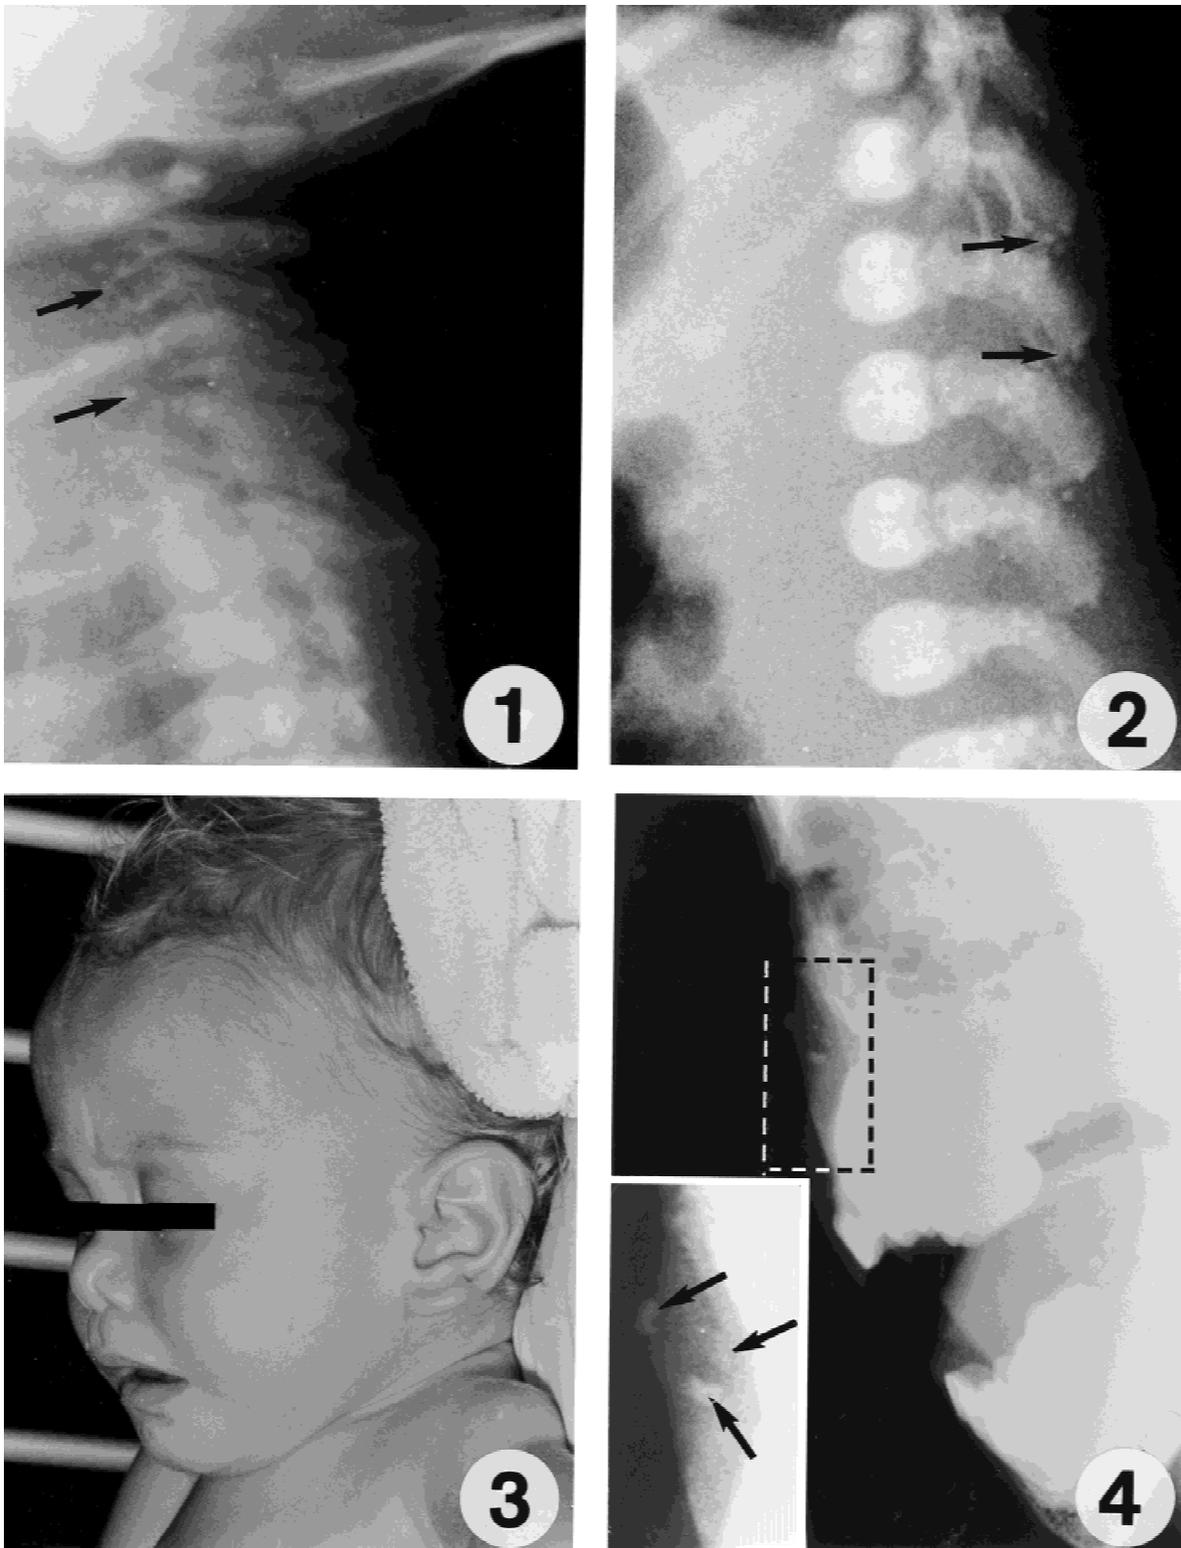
Lateral cervical radiograph at 2 days of age. There is extensive stippling (arrows) in the bodies of the upper cervical vertebrae.
